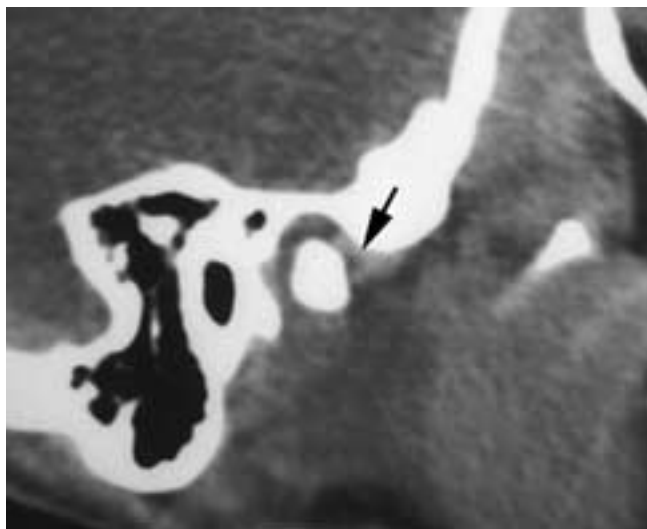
Direct sagittal CT scan with a soft-tissue setting depicting an anteriorly displaced disk. The image of the disk has a relatively high CT attenuation contrasted against the fat close to the lateral pterygoid muscle. The arrow points to the thin portion of the disk.
